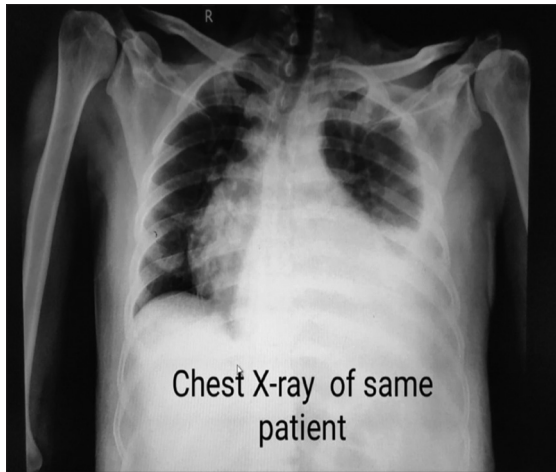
Chest X-ray showing a left hydrothorax due to rupture of splenic pseudocyst
